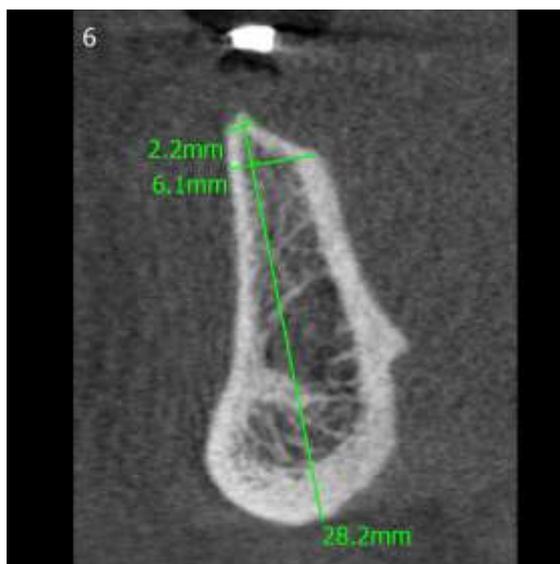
CBCT wrt region 33 and 43
